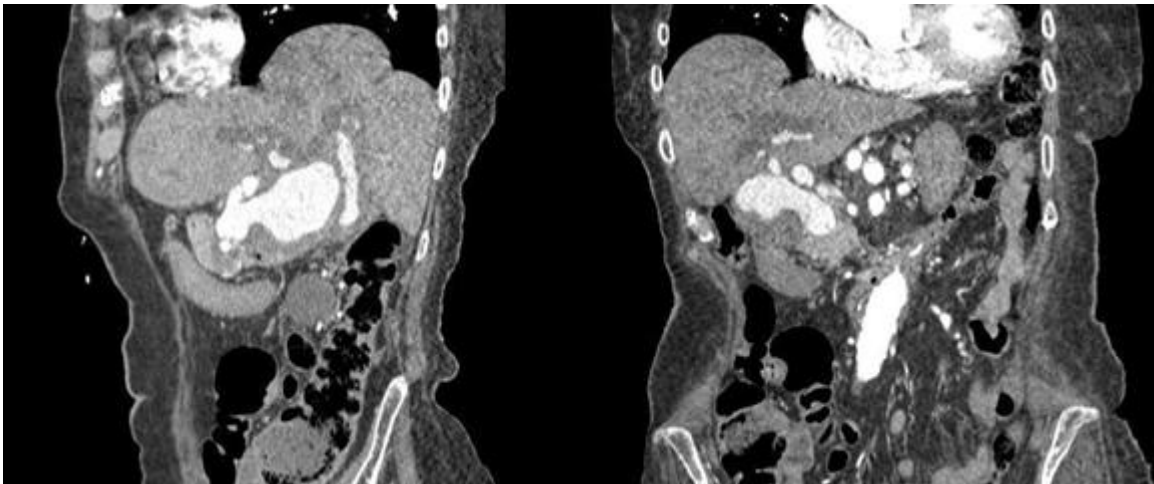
Proper hepatic artery aneurysm and right hepatic artery aneurysm in CT angiography of the splanchnic vessels.
